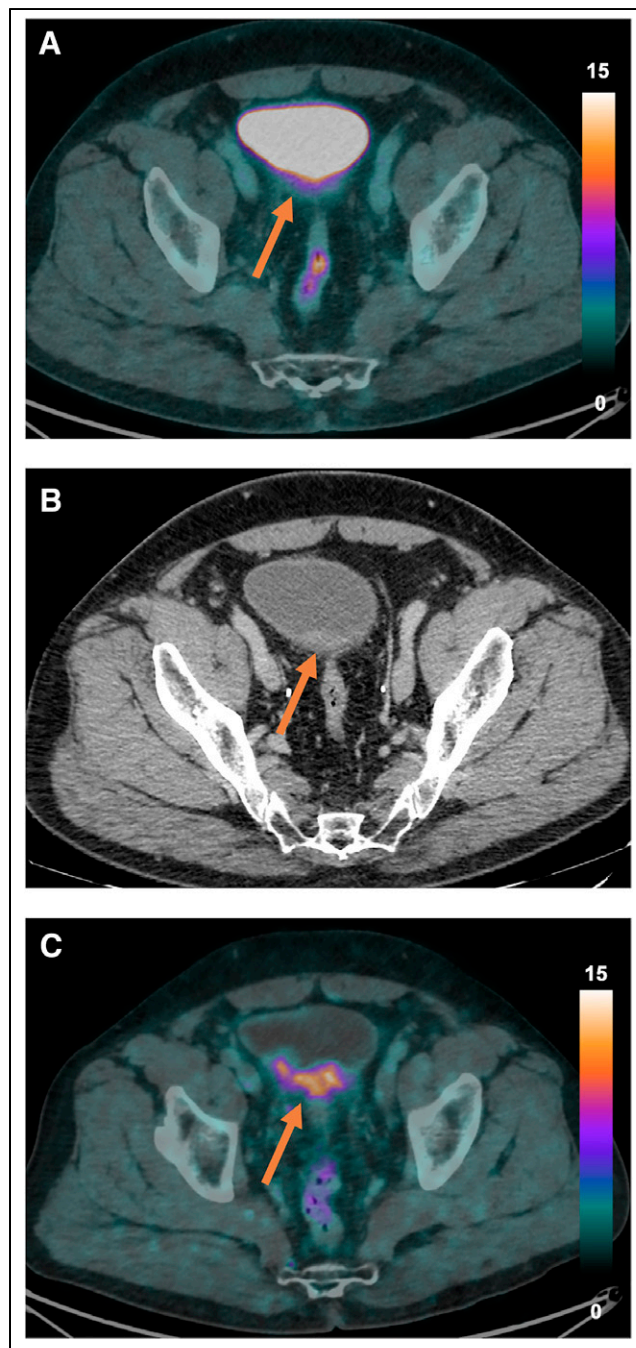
Primary tumor. On ^{18}F -FDG PET/CT (A, arrow), urinary activity within bladder hindered visualization of tumor. Conversely, on ceCT (B, arrow), primary tumor was identified as pathologic thickening of posterior bladder wall, showing intense and inhomogeneous $^{64}\text{CuCl}_2$ uptake (C, arrow). Uptake intensity is expressed in SUV.
